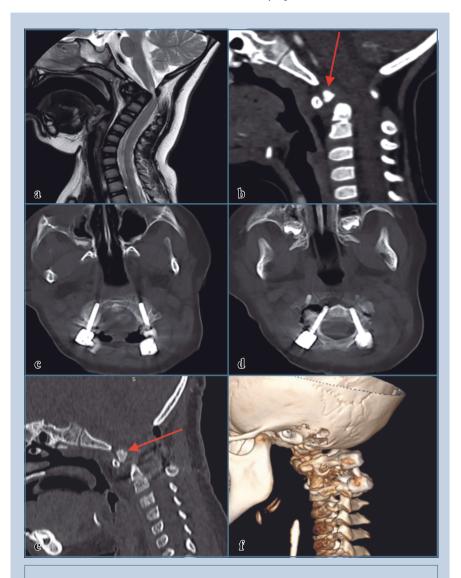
Data of examination of a three-year-old female patient: a − MRI scan of the cervical spine in T2-weighted mode, sagittal plane in the flexion position; b − MSCT scan of the cervical spine in the sagittal plane before surgery, the C2 os odontoideum is marked with an arrow; c − MSCT scan of the position of the fixation instrumentation elements at the level of the C1 vertebra; d − MSCT scan of the position of the fixation instrumentation elements at the level of the C2 vertebra; e − MSCT scan of the cervical spine in the sagittal plane in the flexion position after surgery, the C2 os odontoideum is marked with an arrow; f − MSCT scan with 3D reconstruction of the cervical spine after surgery
